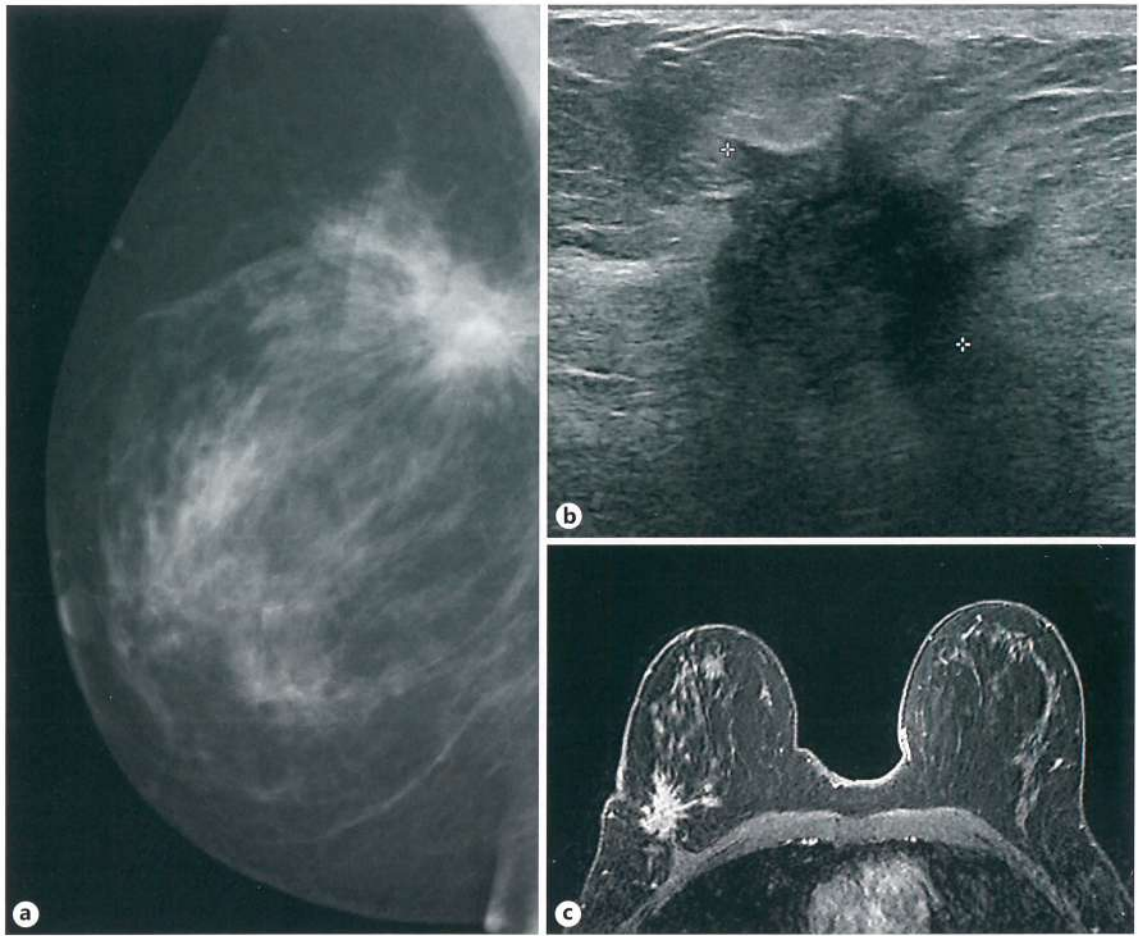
Imaging of invasive ductal carcinoma. This lesion is located in the upper-outer quadrant of the right breast and is visible as a stellate opacity on mammography (a). Ultrasound shows a hypoechoic lesion with irregular borders and posterior acoustic shadowing (b). The lesion is highly suspicious also on magnetic resonance imaging (c).
